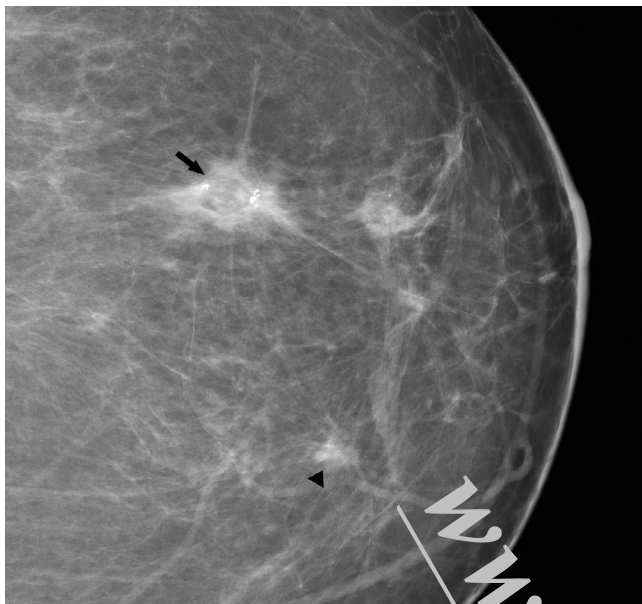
Postoperative Scar. A surveillance mammogram on a patient who has undergone a previous wide excision for a screen-detected cancer. The surgical scar (*arrow*) contains an area of lucency and coarse calcifications indicating associated fat necrosis. A small spiculated mass is demonstrated adjacent to the surgical scar (*arrowhead*); this was found to be a recurrent tumour on ultrasound-guided biopsy.
